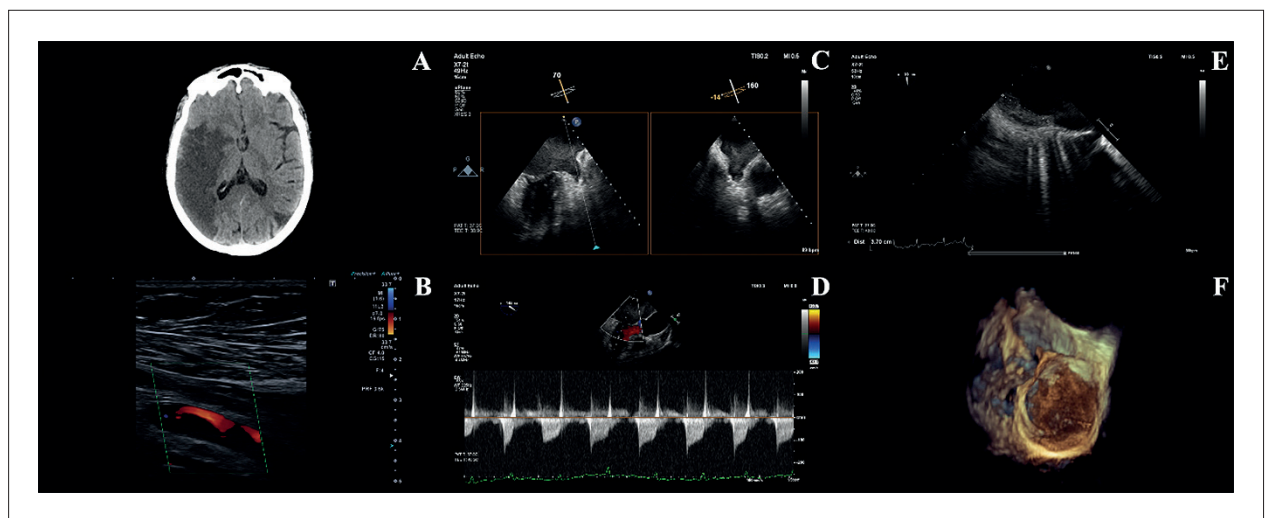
Multimodality imaging findings; A) Brain computed tomography performed three days after admission showing an evolved cortico-subcortical ischemic lesion in the right temporoparietal region; B) Upper-limb arterial Doppler ultrasound of the right subclavian artery demonstrating arterial occlusion; C) Transesophageal echocardiography showing the LA appendage with marked spontaneous echocardiographic contrast and no organized thrombus; D) Transesophageal echocardiographic assessment of the mitral valve demonstrating features of rheumatic mitral stenosis, with spectral Doppler findings consistent with significant valvular obstruction; E) Two-dimensional transesophageal echocardiographic image demonstrating a large mural thrombus adherent to the lateral and posterior walls of the left atrium, measuring up to 37 mm in its longest axis; F) Live three-dimensional transesophageal echocardiographic imaging of the LA mural thrombus
